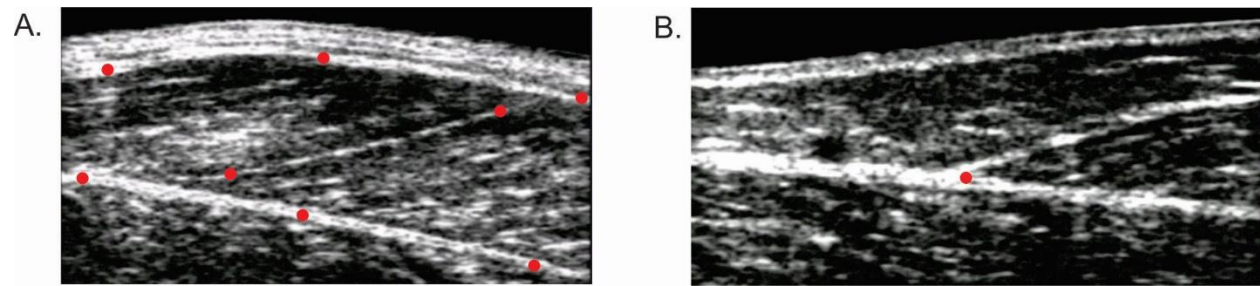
B-mode ultrasound images of the MG muscle belly (A) and MG muscle-tendon junction (B). Red dots indicate digitized points that were used to determine time-varying fascicle lengths and pennation angles from (A) and tendon lengths from (B).
